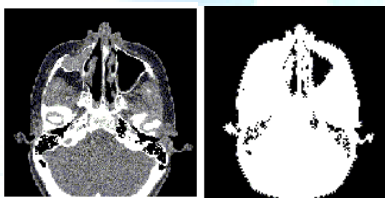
CT image (Left) & down sampled CT Image (Right)
